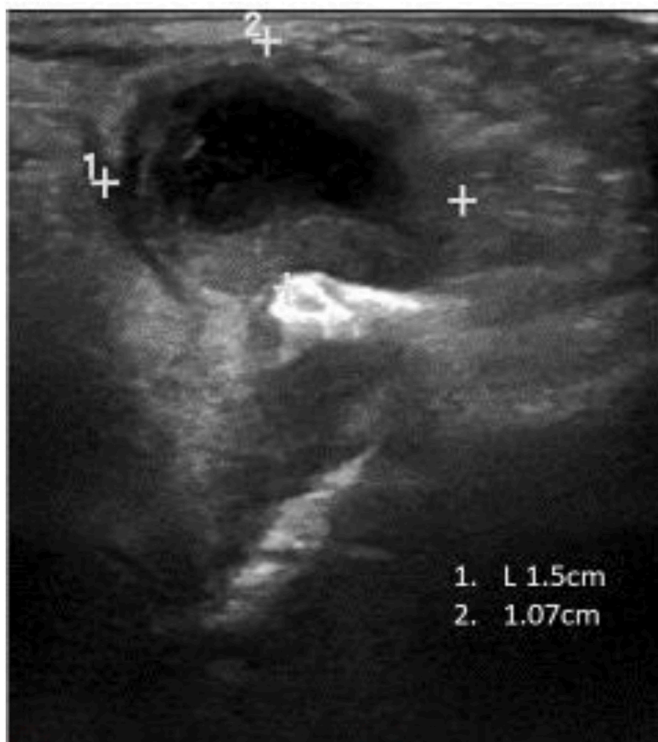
Real time ultrasound of mass below right eye. The scans and measurements indicate a complex thick-walled cystic lesion in subcutaneous tissues of the orbit, measuring approximately 1.5 cm horizontally X 1.07 cm anterior-posteriorly. The companion Doppler studies indicated prominent surrounding vascularity.
